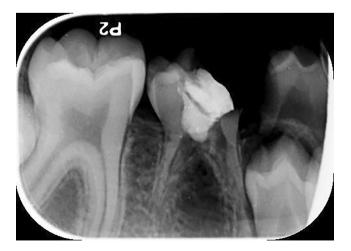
Premolar agenesis (PA) radiograph of the patient in the second session before placing the final restoration.
